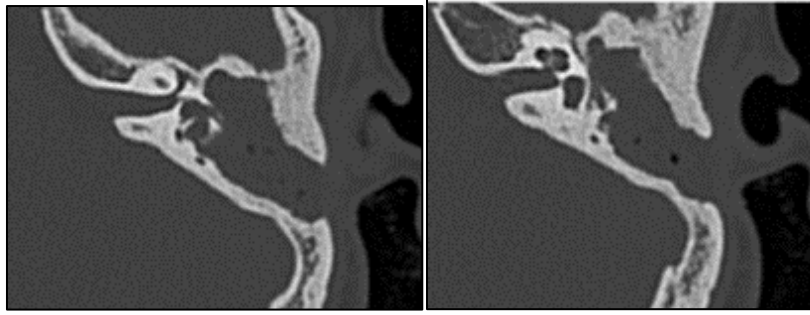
CT axial images of Lateral SCC erosion (left) – Thrombosis of the left sigmoid sinus (right)
